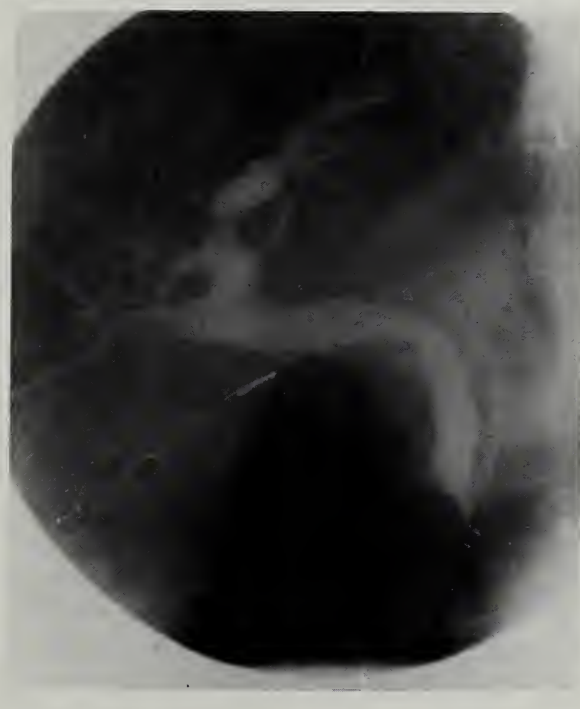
Radiograph from ERCP showing minimal narrowing of the distal common bile duct but no apparent dilatation.
